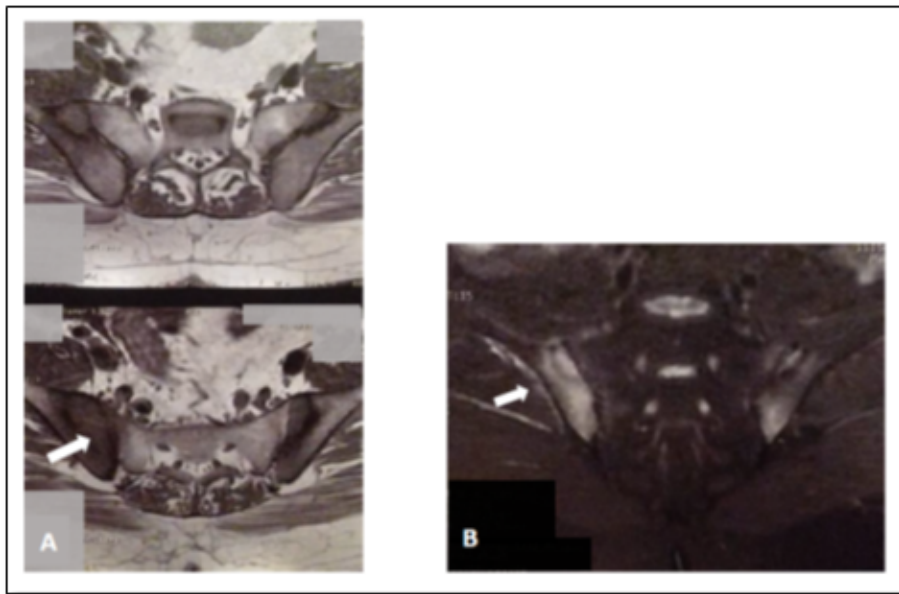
A) T1-weighted coronal oblique image showing periarticular hypo-intensity with greater affecting of the right sacroiliac joint. B) On the STIR sequence, a hyper-intense zone compatible with bone marrow edema.
